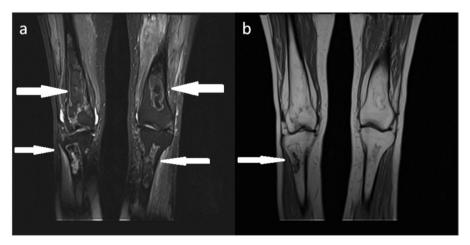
June 2, 2020: (a) MRI coronal T2 fat saturation both legs showing the serpiginous geographic abnormal signal area in the bilateral meta-diaphysis of the tibia and femur in favor of bony infarcts. (Arrow indicates bone involvements.) (b) MRI coronal T1w of both legs. (Arrow indicates bone involvements).
